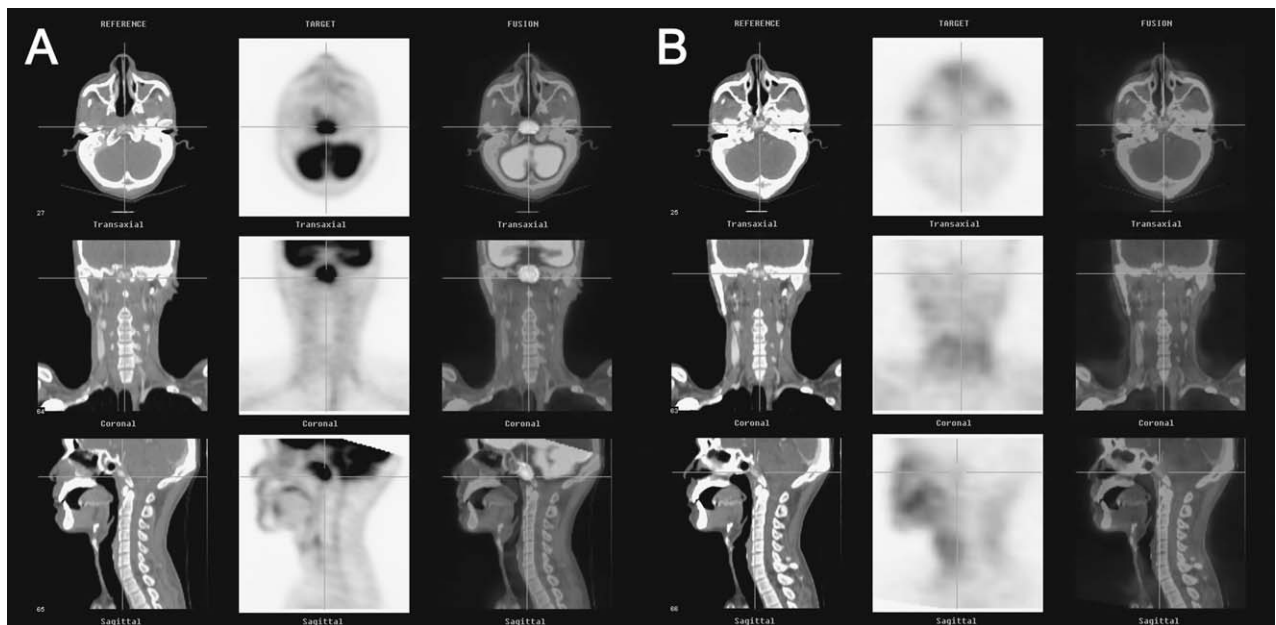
(A) CT (left), FDG PET (middle) and fused images (right) of the nasopharyngeal region. (B) CT (left), TI-201 SPECT (middle) and fused images (right) of the nasopharyngeal region. An example of FDG PET false-positive but TI-201 SPECT true-negative ORN at nasopharyngeal region.
